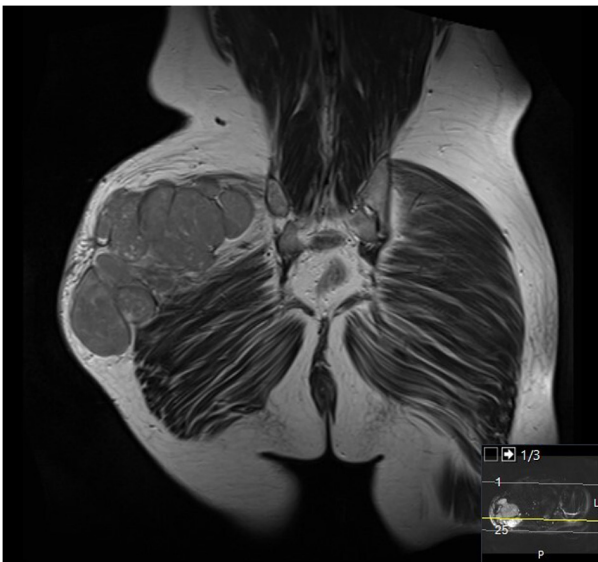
MRI coronal view of the tumor (2012). MRI, magnetic resonance imaging.
